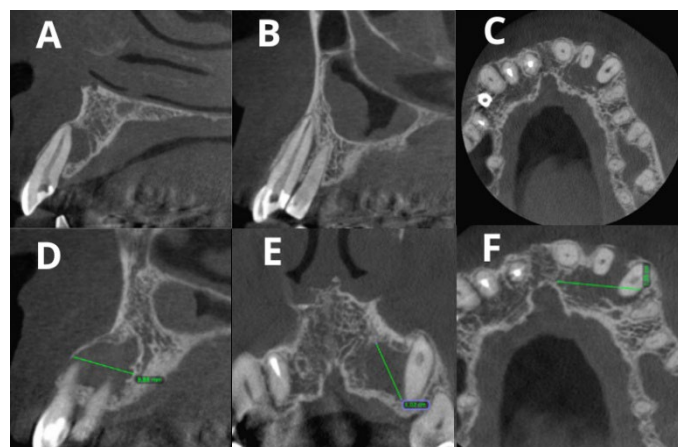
A) Parasagittal section of #22 on high-resolution CBCT; B) Parasagittal section of tooth #23 retreated; C) Axial section of the maxilla; D) Buccopalatal measurement on sagittal view; E) craniocaudal measurement on coronal view; F) Mesiolateral measurement on axial view
